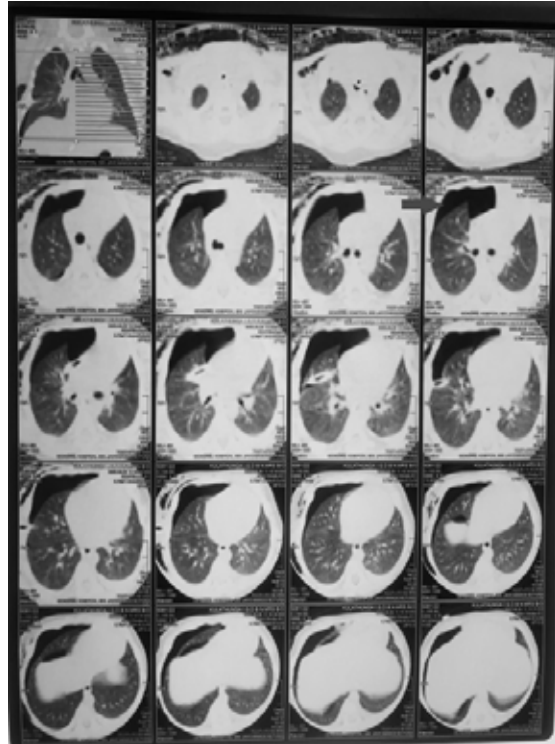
Contrast enhanced CT chest showing right sided pneumothorax (red arrow) without any lung parenchymal abnormalities
